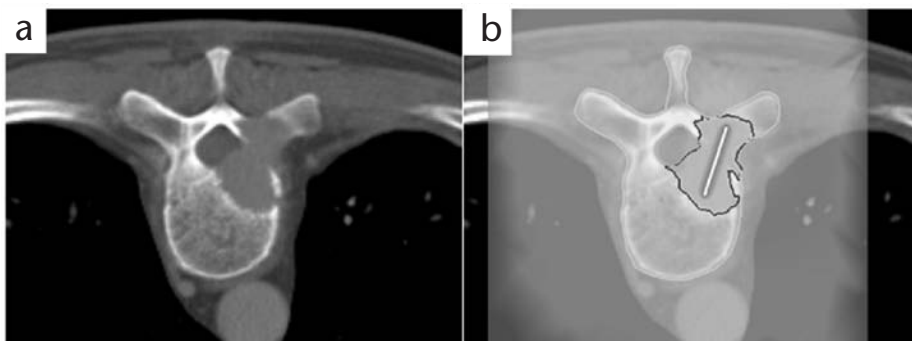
(a) CT image of target vertebra with virtual lesion embedded. (b) Fiber position within the vertebra can be optimized according to color contour maps overlaid onto the CT that show the PDT dose within the lesion and surrounding structures.
